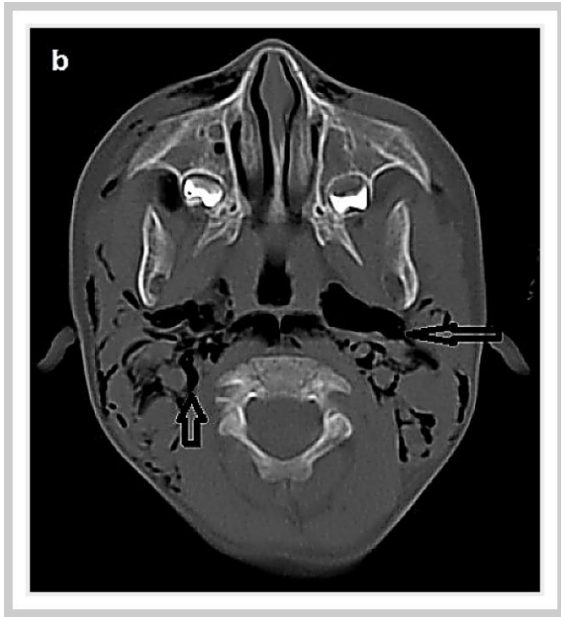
Massive subcutaneous emphysema dissecting along the layers of cervical fascia is seen on axial cervical CT (black arrows).
